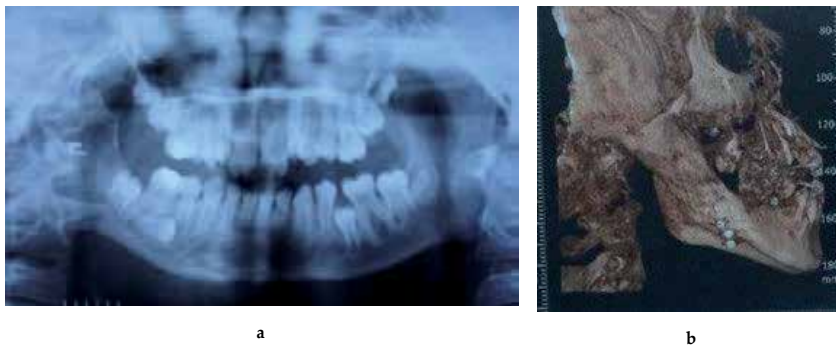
a) Panoramic radiograph of re-ankylosis after previous costochondral grafting b) 3D CT showing complete bony ankylosis of the right condyle.
